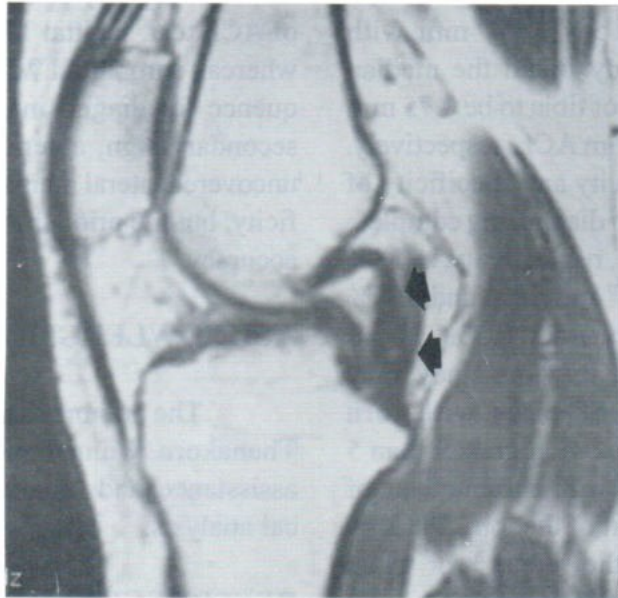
Present buckling of PCL. Sagittal T1-weighted MR image reveals posterior angulation of the PCL. The PCL is outlined by the black arrows.
